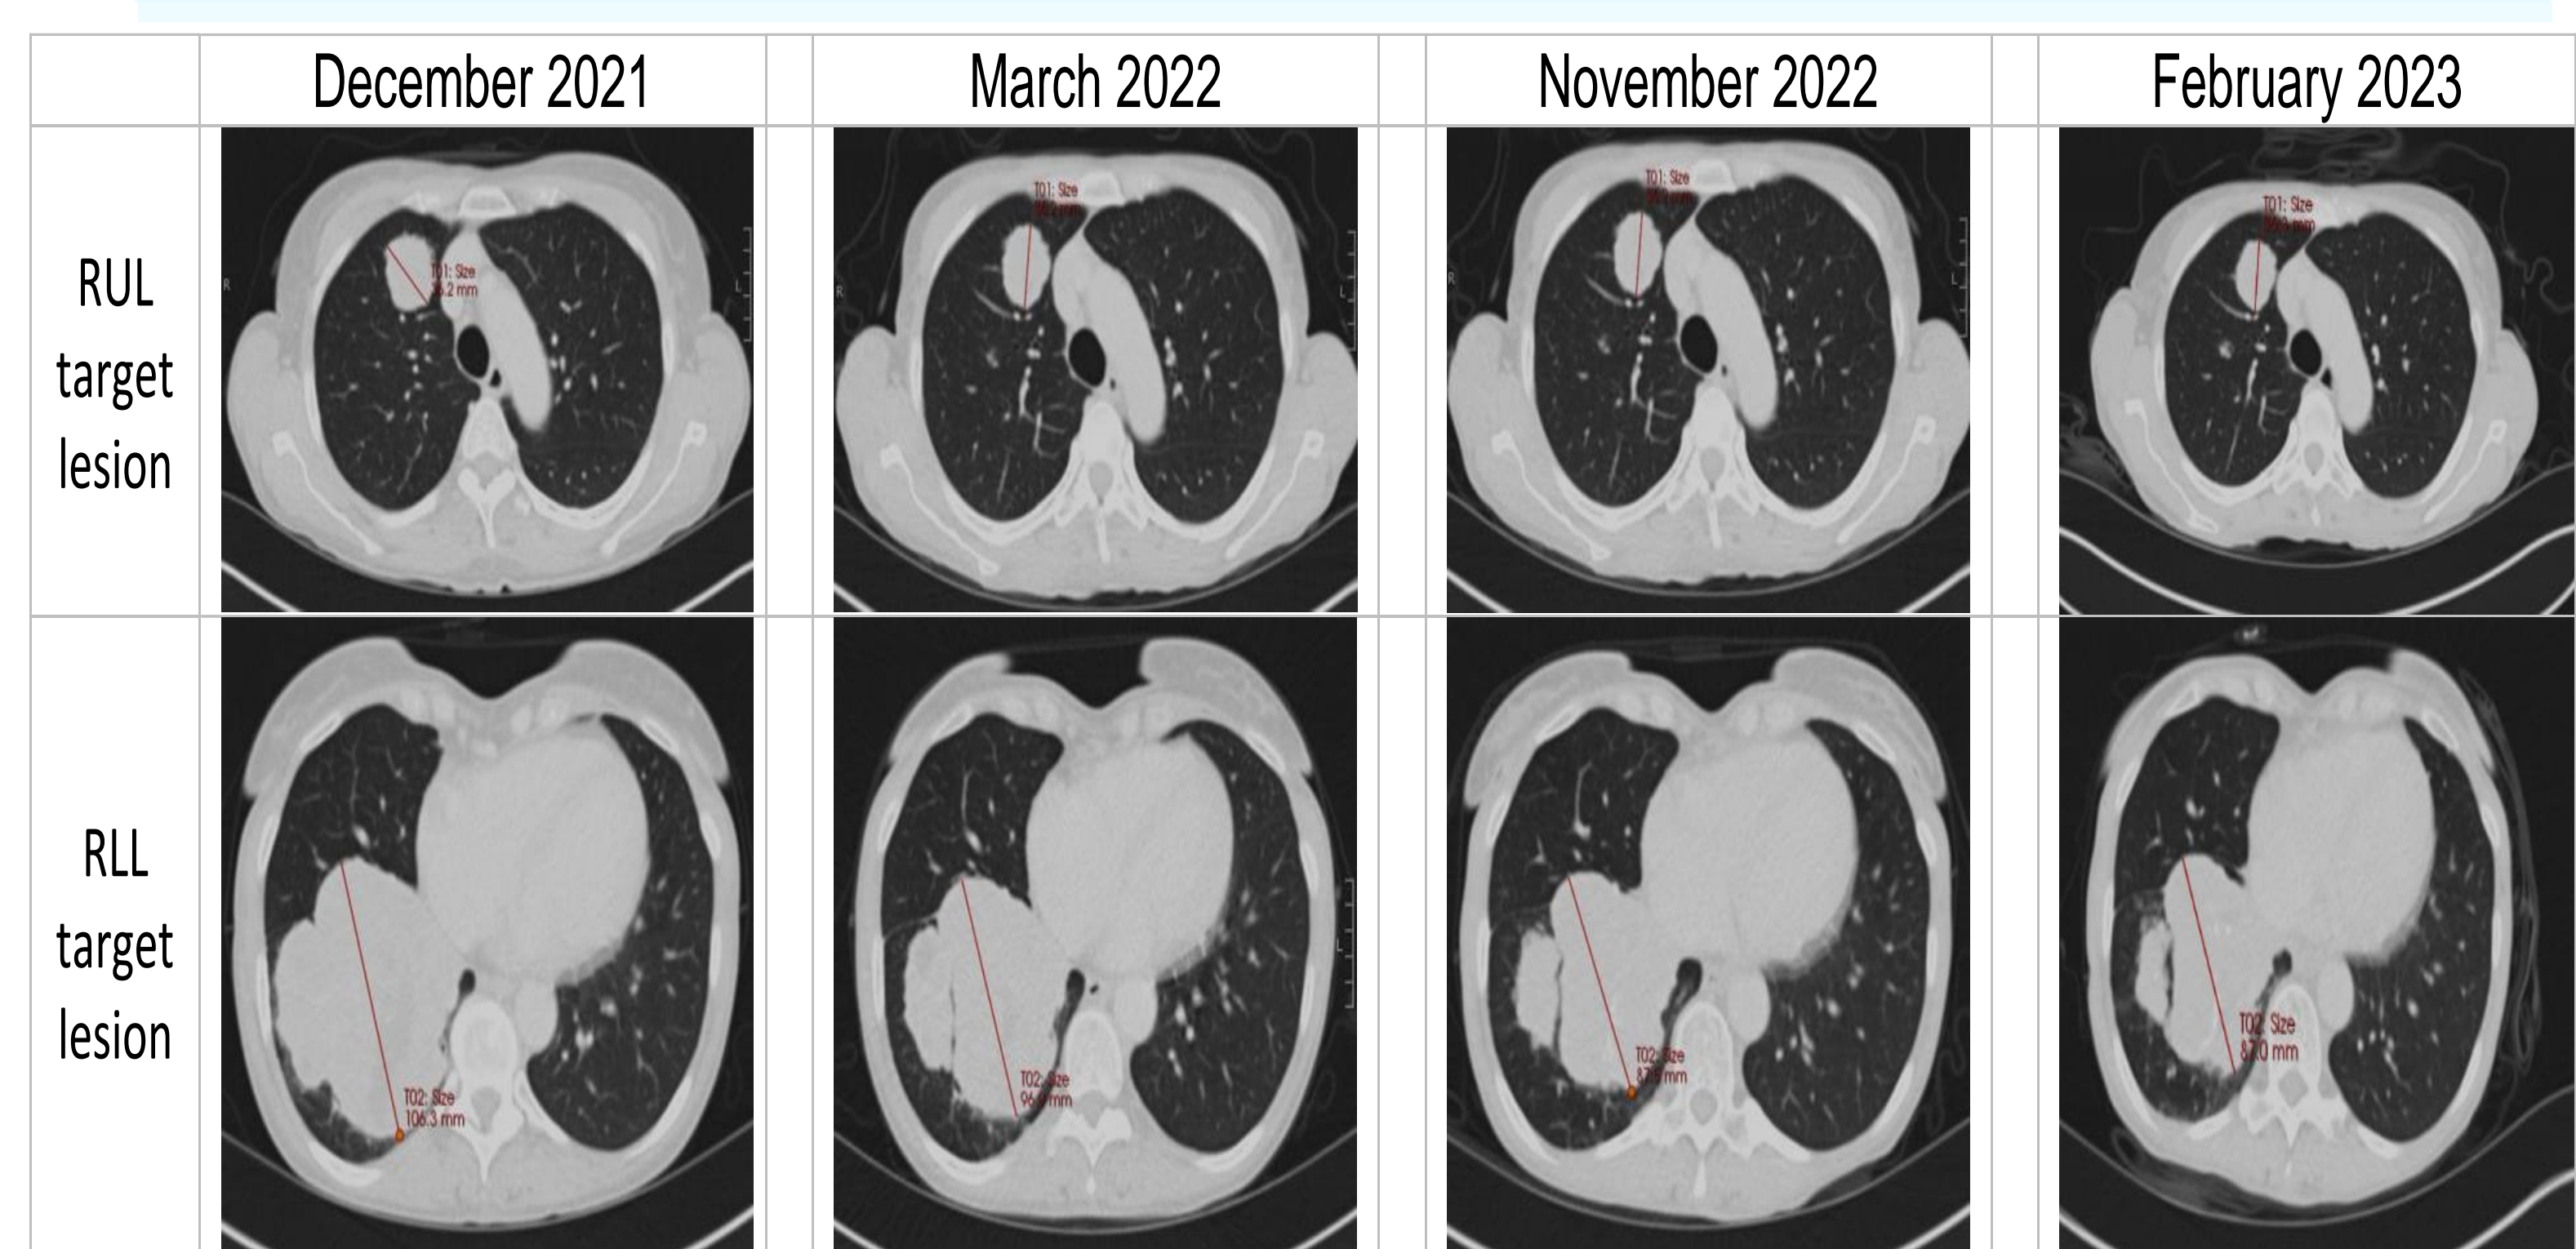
Serial CT imaging of the chest. Images in the top line refer to the right upper lobe (RUL) target lesion and the bottom line shows the right lower lobe (RLL) target lesion. The time points are baseline prior to starting futibatinib, at the first response evaluation time point (3 months after commencing futibatinib), 11 months and the most recent response evaluation scan at 14 months.
